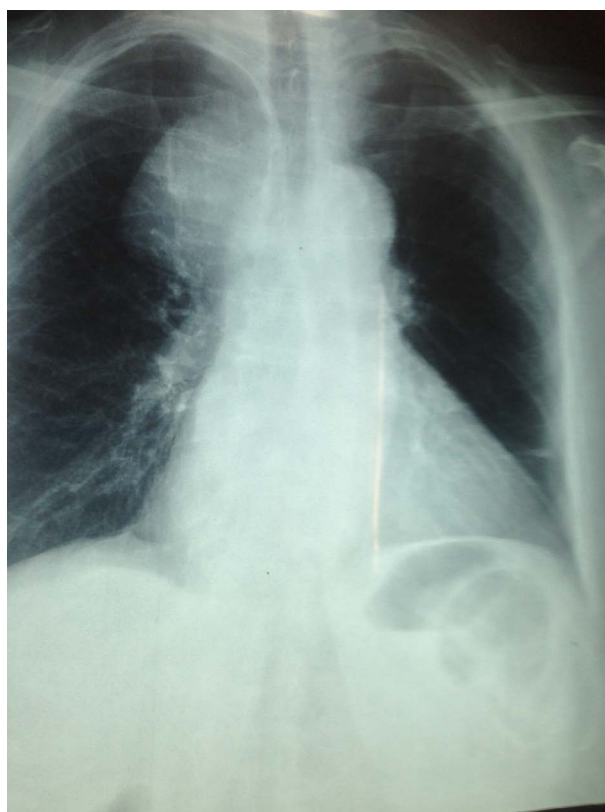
Chest X-ray showed right mediastinal versus paramediastinal well defined opacity, congested perihilar vessels, and mild bilateral pleural effusion.
